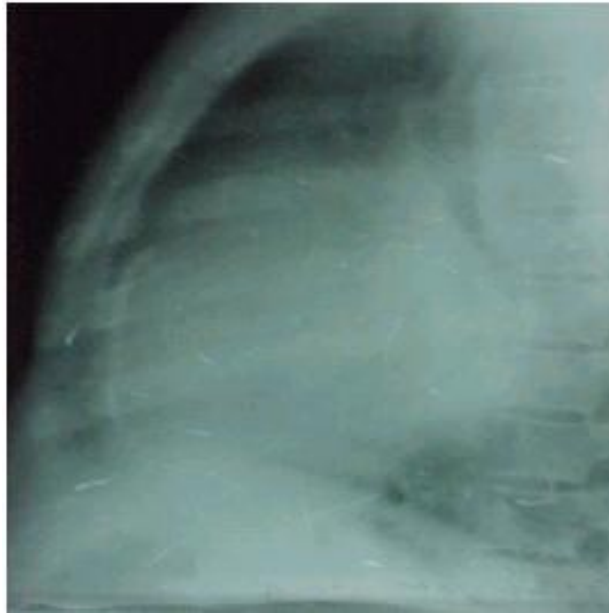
9 Chest X-ray lateral view in a patient with CCP showing pericardial calcification
